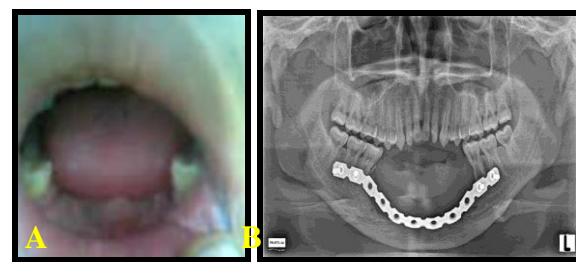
Six months of post operation. A. Showed a satisfactory outcome without signs of recurrence. B. Panoramic X-ray showed the AO plate was installed properly
